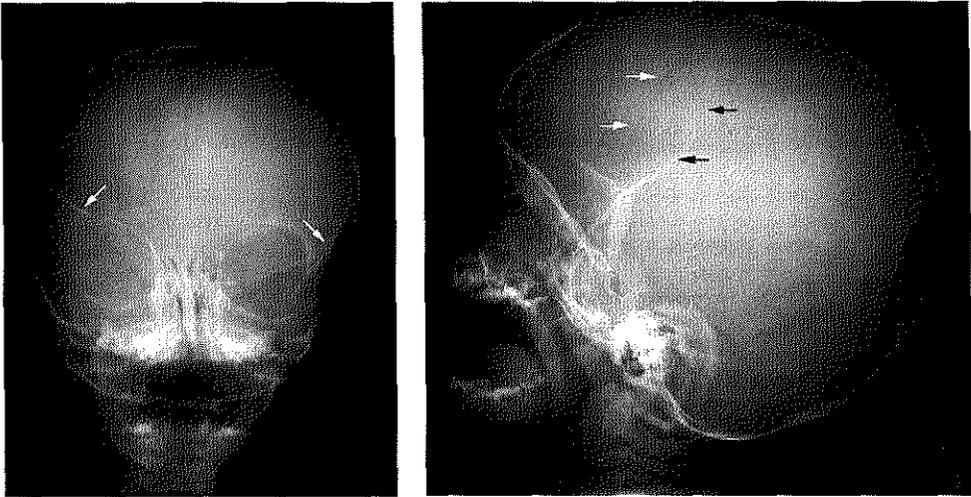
X-ray of unilateral coronal suture synostosis seen from a frontal and a lateral view. On the frontal view the orbit on the synostotic side has an altered shape, referred to as Harlequins' eye, due to the displacement of the sphenoid wing (indicated on both sides by arrows). From the side, the coronal suture on the affected side is visible as a white line (black arrows), while the non-synostotic suture is reflected as a black line (white arrows).
